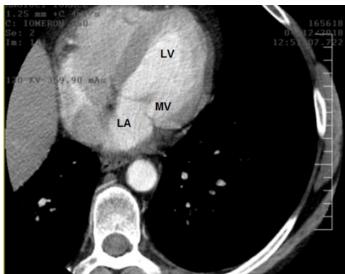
Computed tomography of the heart. Mitral valve is between the left ventricle and the left atrium.
